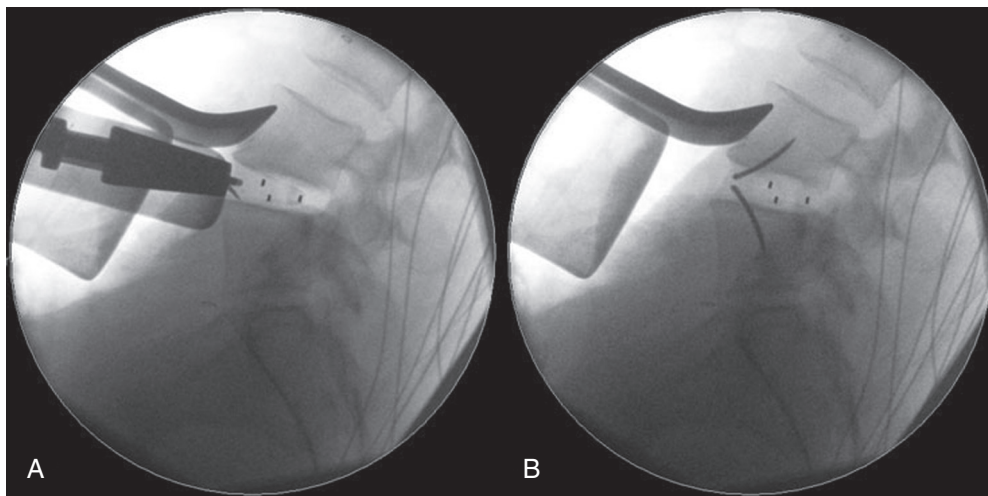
Intraoperative radiographs of the ROI-A cage with incorporated plating devices. A, Insertion of the device at L4–L5. B, After deployment of the screwless plating devices.
